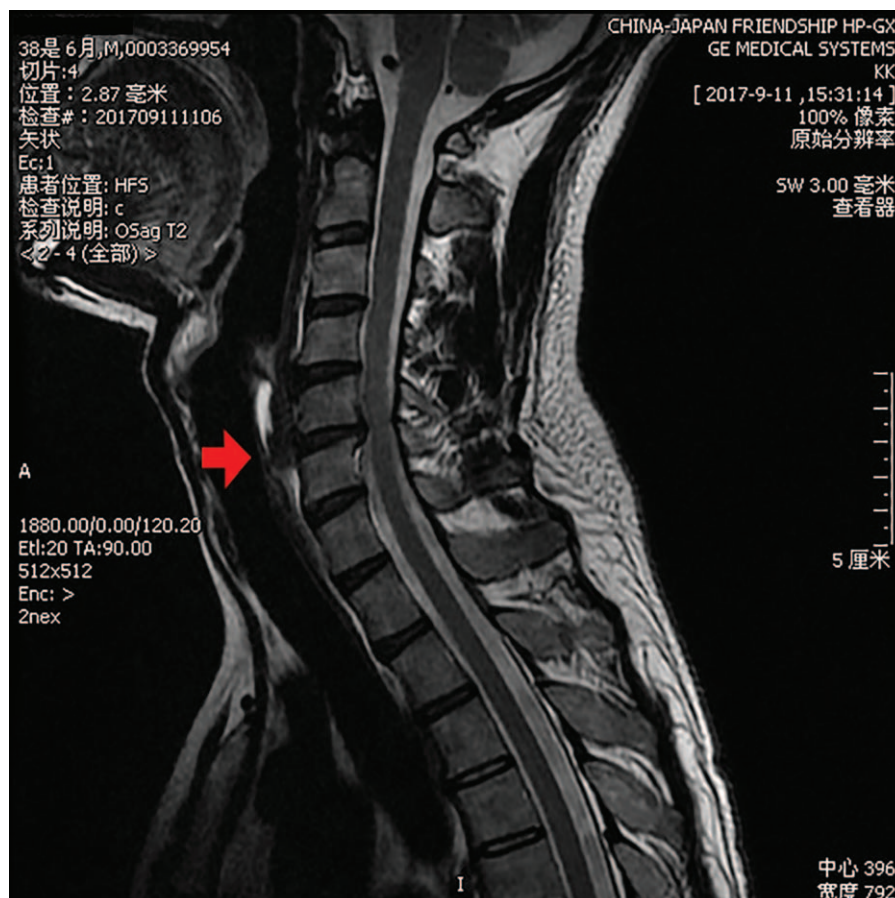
Magnetic resonance imaging T2 fat-suppression sequences show high signal in the longus colli muscle located at the level of C5 and C6 (red arrow).
